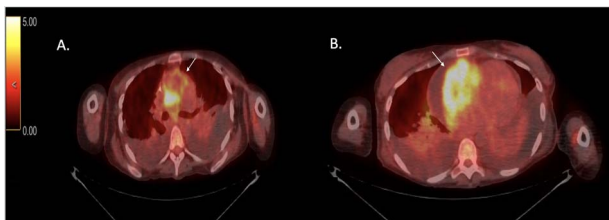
(A) 18-FDG PET/CT image showing increased fluorodeoxyglucose circumferential uptake of the ascending aorta (white arrow). (B) 18-FDG PET/CT image showing increased fluorodeoxyglucose uptake of the right atrium (white arrow).
